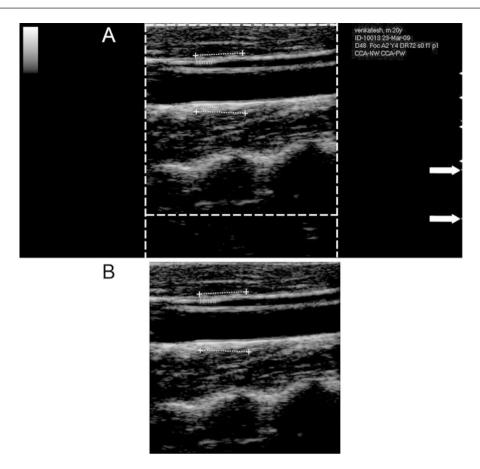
CALEX 3.0 automated cropping. (a) Original image. The *dashed lines* delimit the region containing the ultrasound data. Outside the *dashed lines*, the vertical and horizontal gradients are null. The *white*
